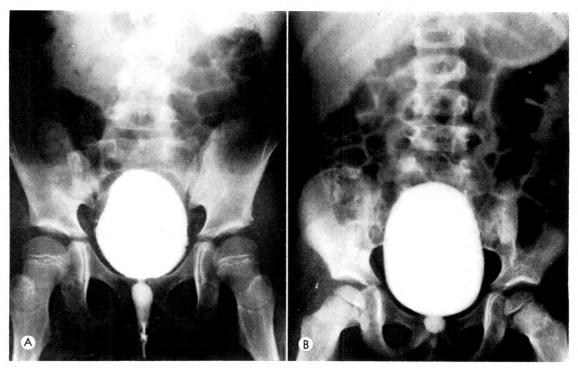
Bladder outlet abnormality without vesicoureteral reflux. (A) Four second cystogram of a $6\frac{1}{2}$ year old female who had a bladder neck contracture with the typical deformity and poststenotic dilatation. Trabeculation of the bladder wall can also be seen. (B) 2.7 second cystogram of a 3 year old female with the same deformity. Roentgenographically it was thought that there was also a distal urethral stenosis, but this was not confirmed cystoscopically.
